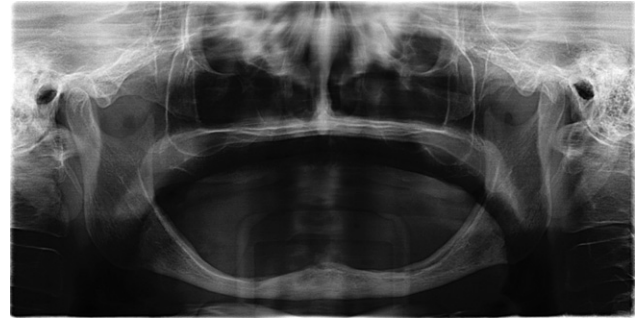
Baseline panoramic radiograph of a patient with extreme resorption of the edentulous mandible.
